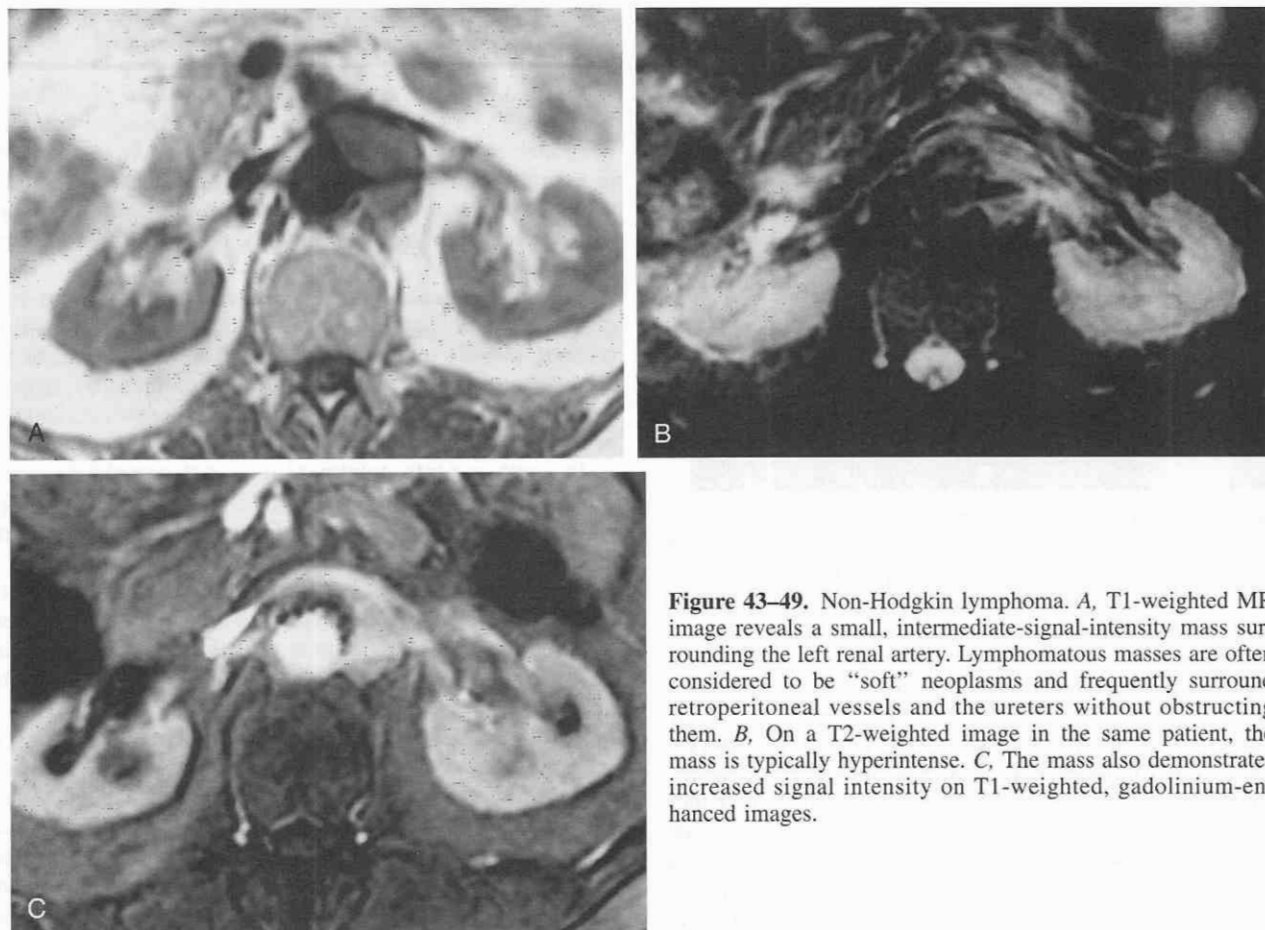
Non-Hodgkin lymphoma. A, T1-weighted MR image reveals a small, intermediate-signal-intensity mass surrounding the left renal artery. Lymphomatous masses are often considered to be “soft” neoplasms and frequently surround retroperitoneal vessels and the ureters without obstructing them. B, On a T2-weighted image in the same patient, the mass is typically hyperintense. C, The mass also demonstrates increased signal intensity on T1-weighted, gadolinium-enhanced images.
